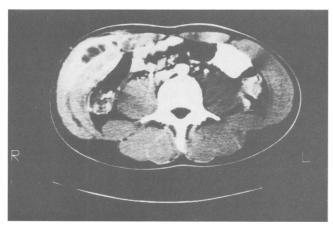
A computed tomographic scan of the abdomen shows pronounced edema and multiple septate, hypolucent abscess cavities within the right internal oblique, external oblique, and rectus abdominis muscles. Note the absence of soft tissue swelling overlying the area of pyomyositis.
